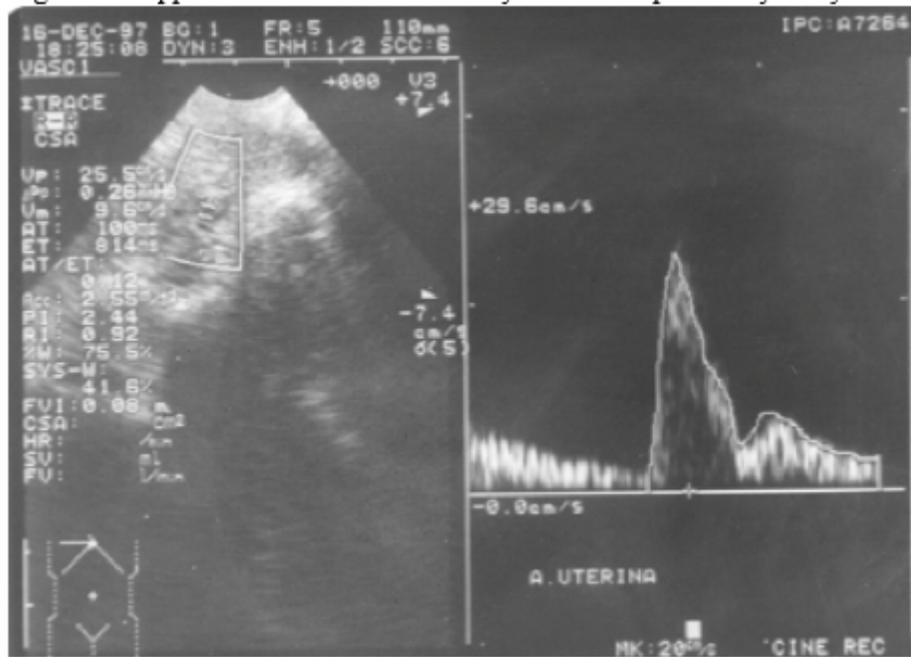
Doppler scan of the uterine artery was accomplished by analysis of the profile of the wave speed and measurement of the pulsatility index (PI) and resistance index (RI).
